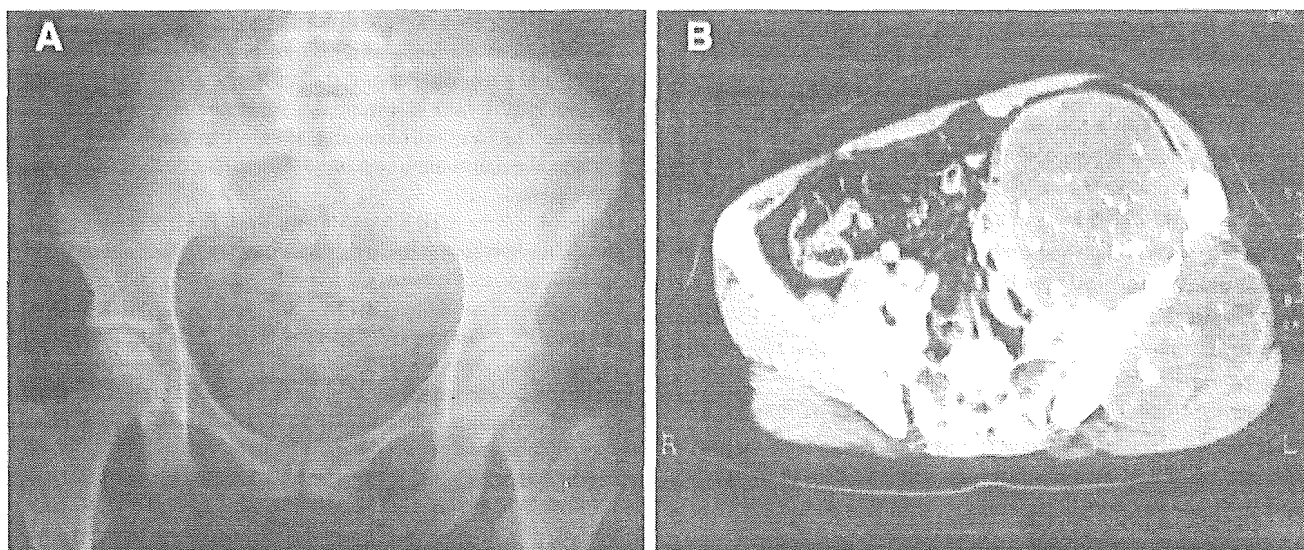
Preoperative plain X-ray (A) and CT (B) of Case 9 with a chondrosarcoma (grade 2) arising from the illium. Huge tumor mass with calcification and bone destruction expands both towards the outside and internally.
